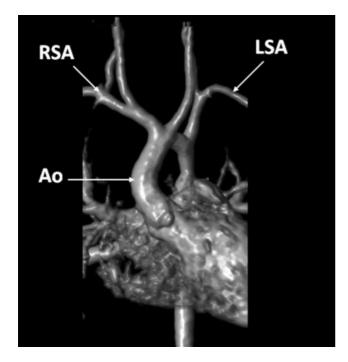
Postnatal magnetic resonance image demonstrating normal origin of the left (LSA) and right (RSA) subclavian arteries Ao. aorta.
